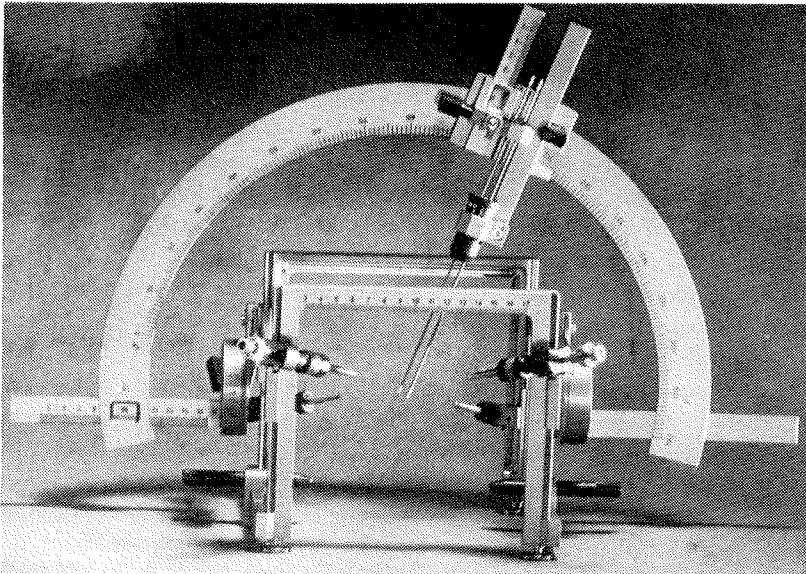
The Leksell stereotactic system. The frame may be used with conventional x-ray, CT or magnetic resonance imaging for target location.
